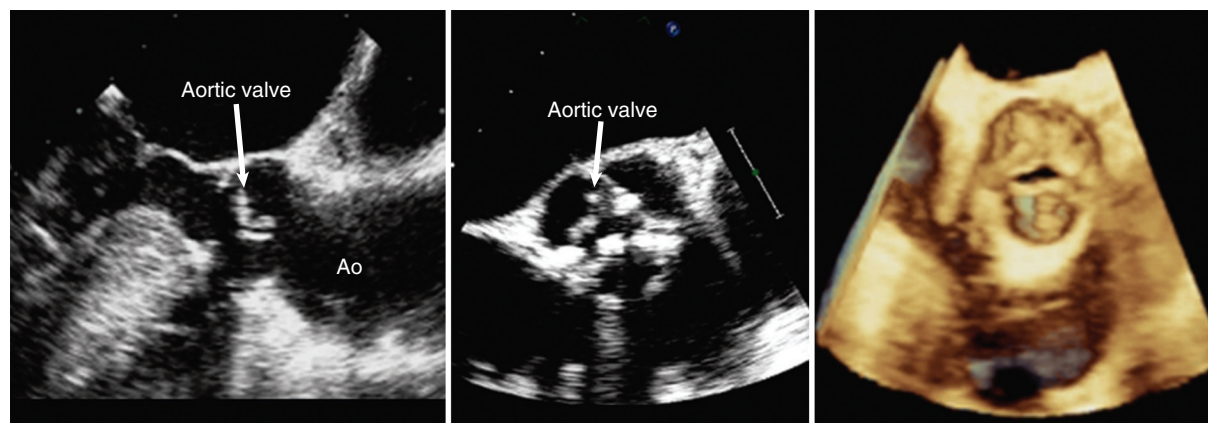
Systolic transesophageal images of valvular aortic stenosis in a patient with a tricuspid valve. Left, Two-dimensional long axis. There is minimal opening of the valve. Middle, Short axis. Right, Three-dimensional image. The latter two views better demonstrate the distribution of calcium.
